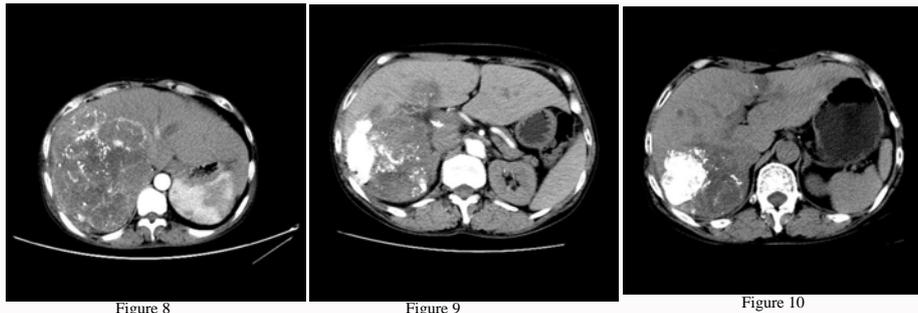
On December 30, 2015, the enhanced CT reexamination showed that the maximum diameter of the tumor had progressed to 14.38 cm × 17.20 cm (Figure 8). After 3 months treatment of TACE combined with apatinib, the tumor had remarkably shrunk to 11.20 cm × 9.37 cm (Figure 9), and 16 months after oral apatinib treatment, the tumor continued to shrink to 7.81 cm × 8.87 cm and other intrahepatic metastasis had also remarkably shrunk (Figure 10).
